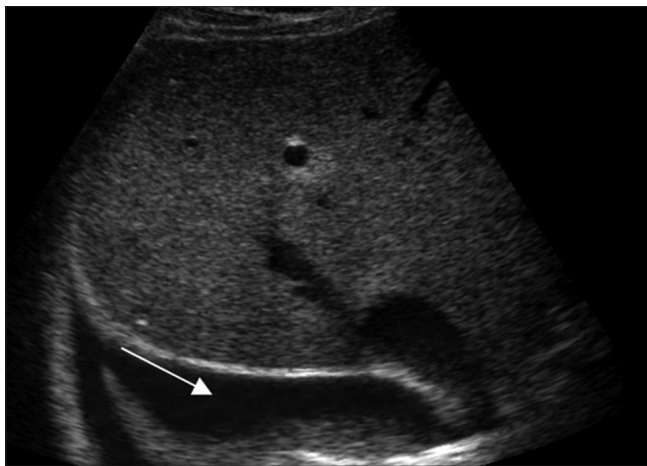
A 42-year-old male patient with dengue fever, ultrasound shows moderate right pleural effusion (arrow)
